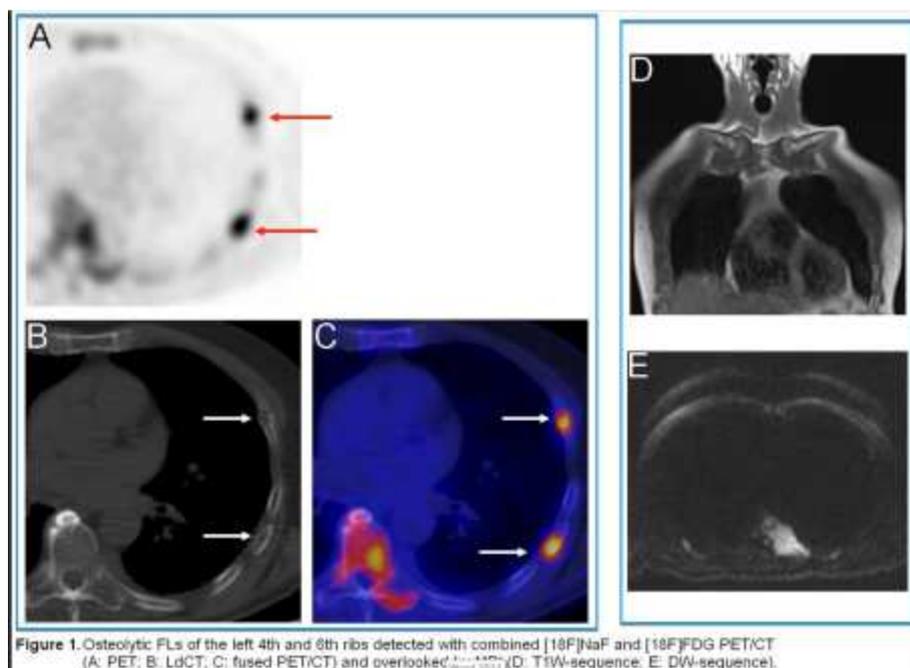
Osteolytic FLs of the left 4th and 5th ribs detected with combined [18F]NaF and [18F]FDG PET/CT (A: PET; B: LdCT; C: fused PET/CT) and overlooked (D: T1W-sequence; E: DW-sequence).
